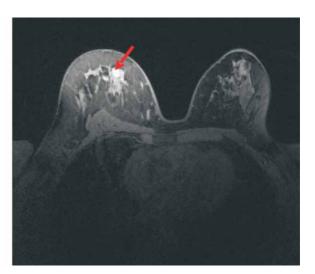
(a and b). Quantitative thermographic signs heat in area of finding: A: Black arrow points to encircled area of raised thermal activity ≥ 1 ° C in upper medial quadrant of right breast; B: Red arrow points to the same lesion of the right breast detected by MRI.
